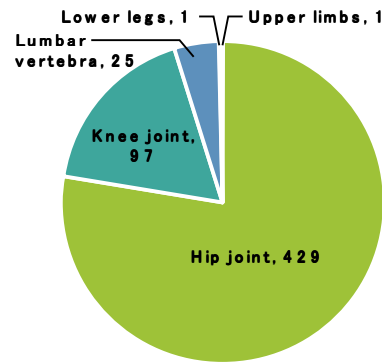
Breakdown of Tomosynthesis Radiography Examinations
